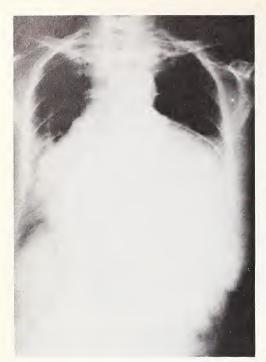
X-ray of the chest on September 30, 1974, showing markedly enlarged heart shadow.
